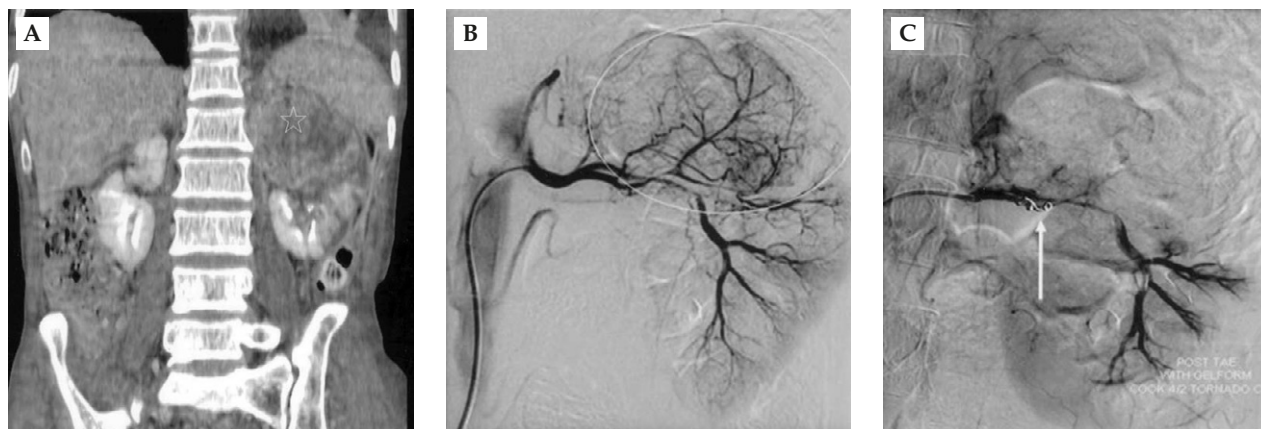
(A) Computed tomography: coronal reconstructive section shows a 12 × 13 cm mass in the upper pole of the left kidney (star). (B) Angiography shows a hypervascular mass located in the left upper kidney (circle). (C) Selective embolization of the tumor by the metallic coil is successful (arrow).
